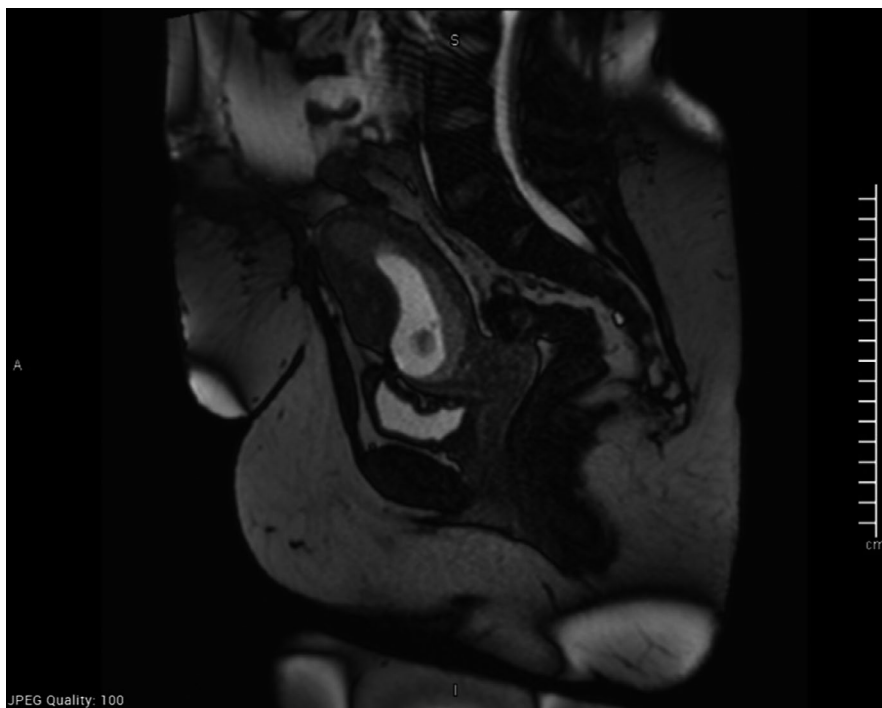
T2 MRI image showing a viable gestational sac lowly implanted and seen bulging in the previous LSCS scars region
